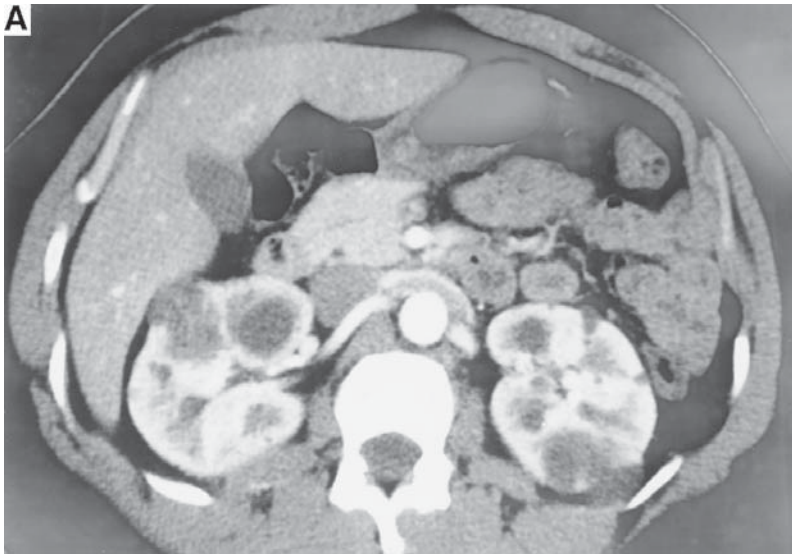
Helical CT scan of a patient with adult polycystic kidney disease, showing various images of an enhancing cystic lesion. (A) Standard image (axial projection), showing multiple cysts and the renal cell carcinoma.
